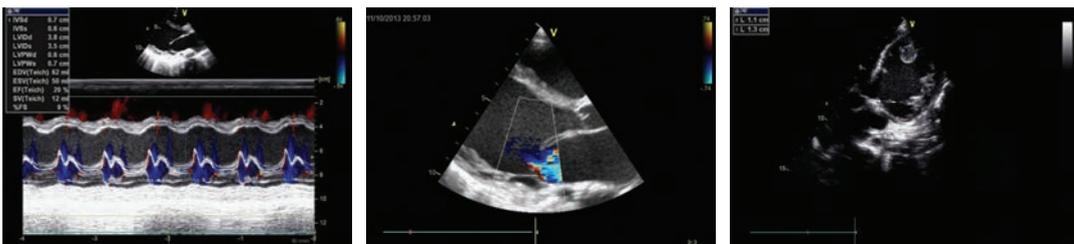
Echocardiographic images in the: 1. M- mode (EF 20%), paradoxical movement of the septum, 2. long axis with global enlargement and mitral insufficiency and 3. 4-chamber orientation with global enlargement, low contractility and appearance of thrombosis into the left ventricle (from own archives).
